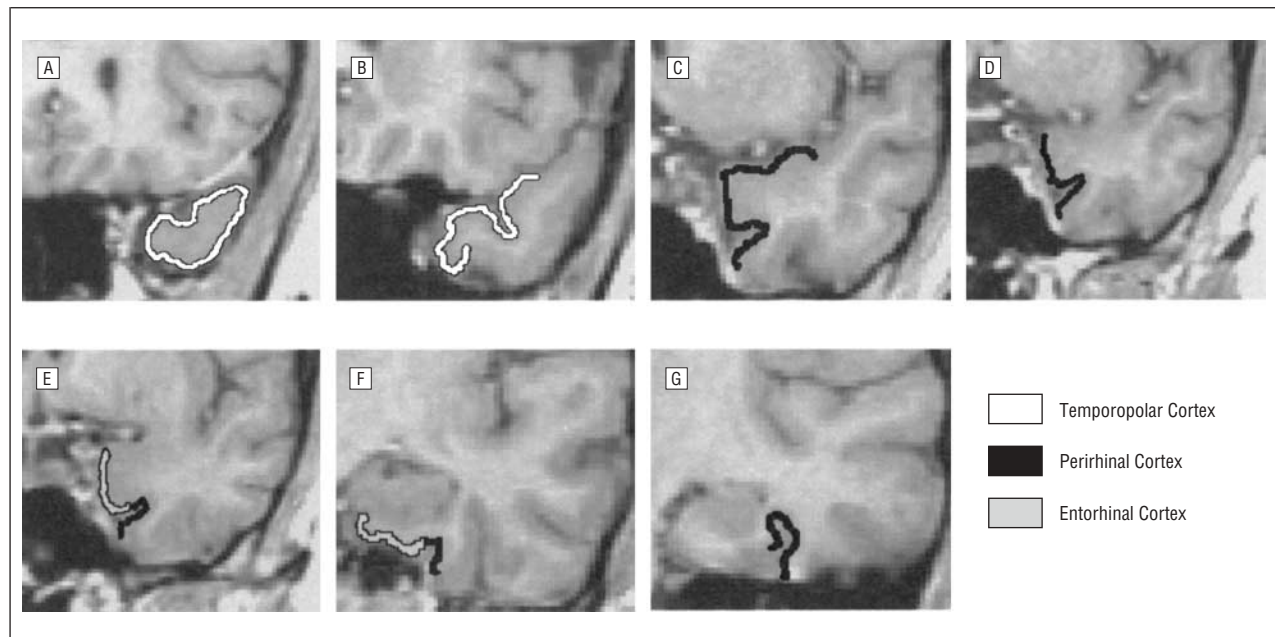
Examples of the regional boundaries of anterior ventromedial temporal lobe regions as operationally defined on coronal magnetic resonance images. Images A through G move progressively in a rostral to caudal direction.
